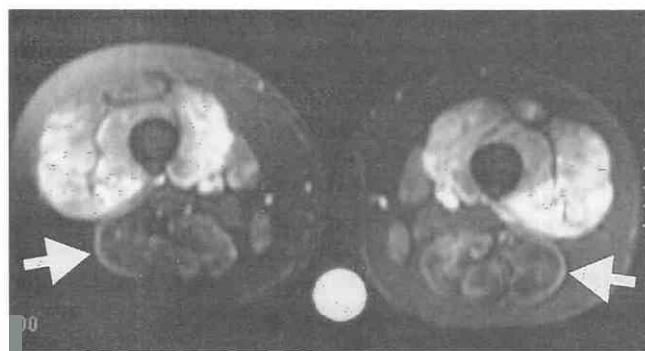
Dermatomyositis in a 13-year-old girl. Axial T2-weighted image (TR = 2500 msec, TE = 80 msec) with fat saturation shows symmetrical increased signal intensity within anterior thigh musculature. The relative sparing of the hamstring muscles posteriorly (arrows) is characteristic.
